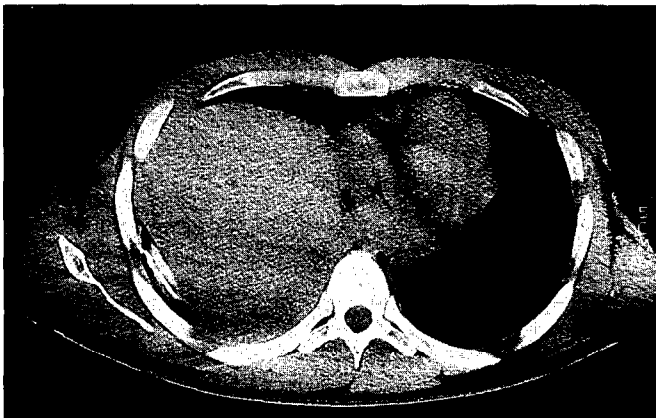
CT section confirms the hepatic elevation to the lower level of the hila. The right diaphragm cannot be visualized
